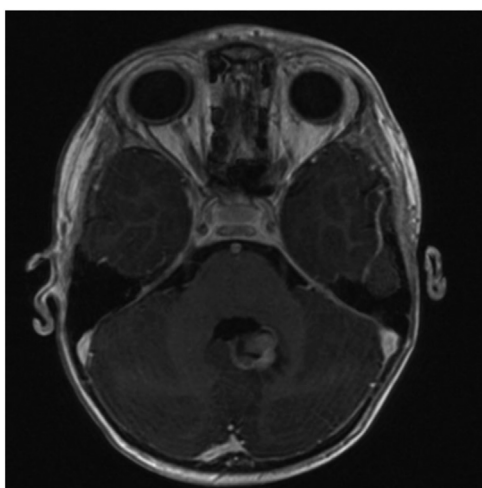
Magnetic resonance imaging showing a solid cystic enhancing lesion in the deep left cerebellum adjacent to the posterior margin of the fourth ventricle. The lesion measured 1.5 × 1.8 cm, causing mild edema in the adjacent brain with significant mass effect.
